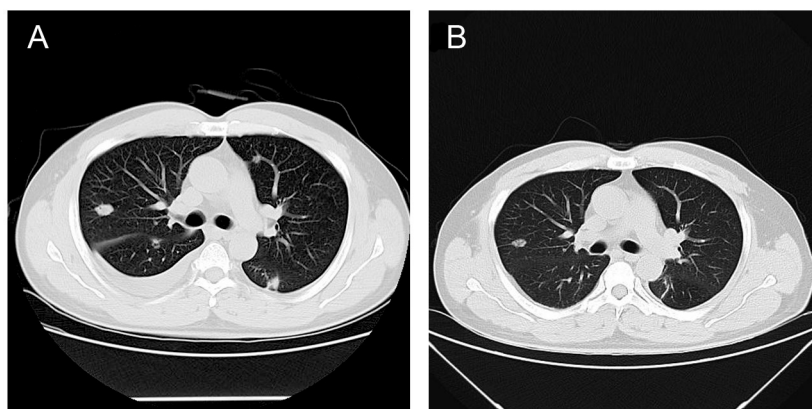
CT scan of a patient with lung metastasis achieved PR after 4 cycles of treatment. A) before treatment; B) after treatment.
